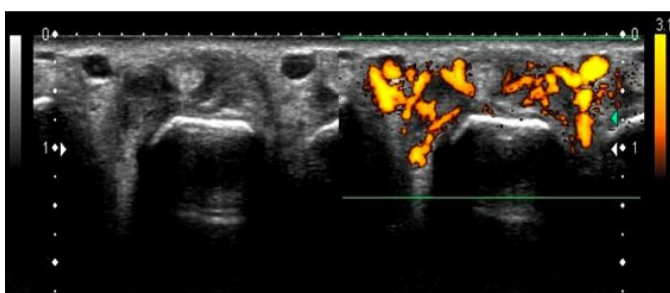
B-mode and power Doppler ultrasound of the left fourth digit in the axial plane. Note the extensive peritendinous extensor thickening with vascular hyperflow at the level of the metacarpophalangeal joint, indicating functional enthesitis. Note: This image had already been presented at the 2017 European Congress of Radiology in electronic poster (EPOS) mode, (<https://dx.doi.org/10.1594/ecr2017/C-0384>). According to the congressional ethics committee, the authors have the right to use it.
